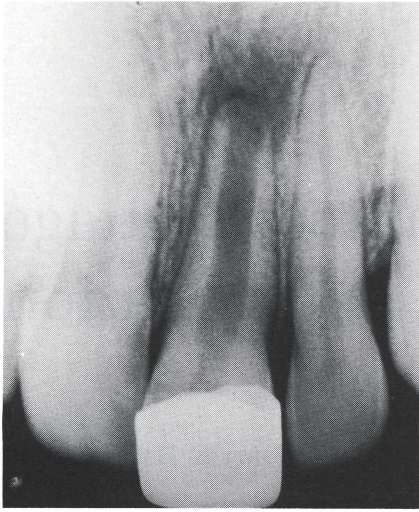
Radiograph of nonvital permanent central incisor before endodontic treatment.
